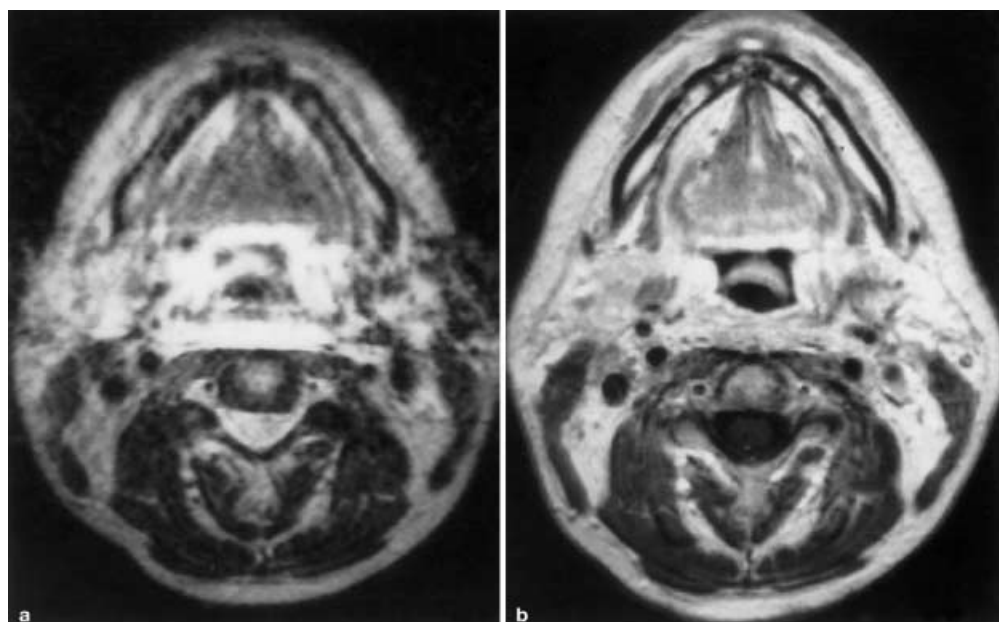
T2-weighted SE MRI (TR 3500 ms, TE 100 ms) 6 months after irradiation (70 Gy) and 5 months after additional irradiation (30 Gy) (squamous cell carcinoma of the hypopharynx; T4, N2, G3). Edema of the ventral neck muscles with hyperintense signal intensity
